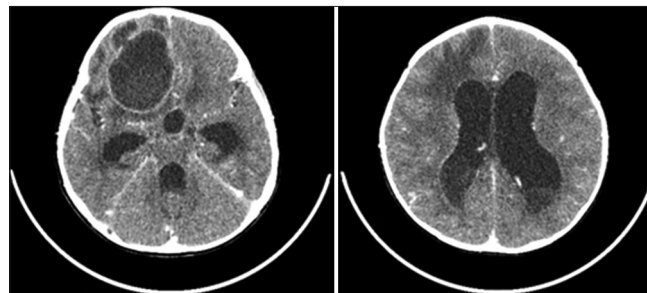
First head CT scan: Abscess cavity in the right frontal region, vasogenic edema, ventricular enlargement
